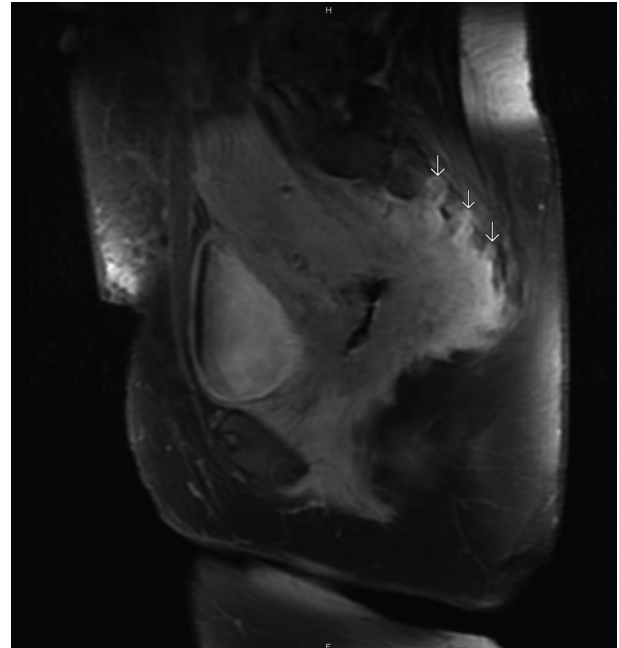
Postpartum magnetic resonance imaging showing a large pelvic mass with extension along sacral roots (arrows), spinal canal, and sciatic nerve tract.
